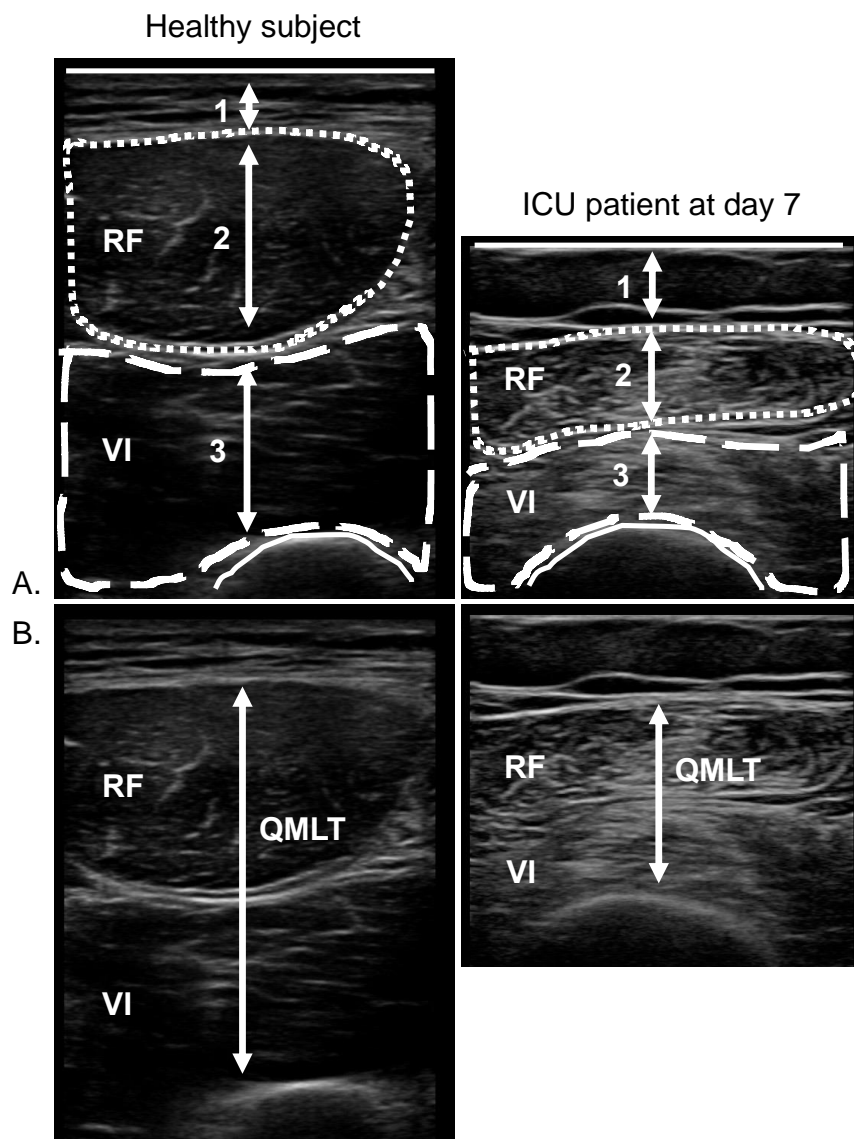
Ultrasound images on a healthy subject and ICU patient at day 7
